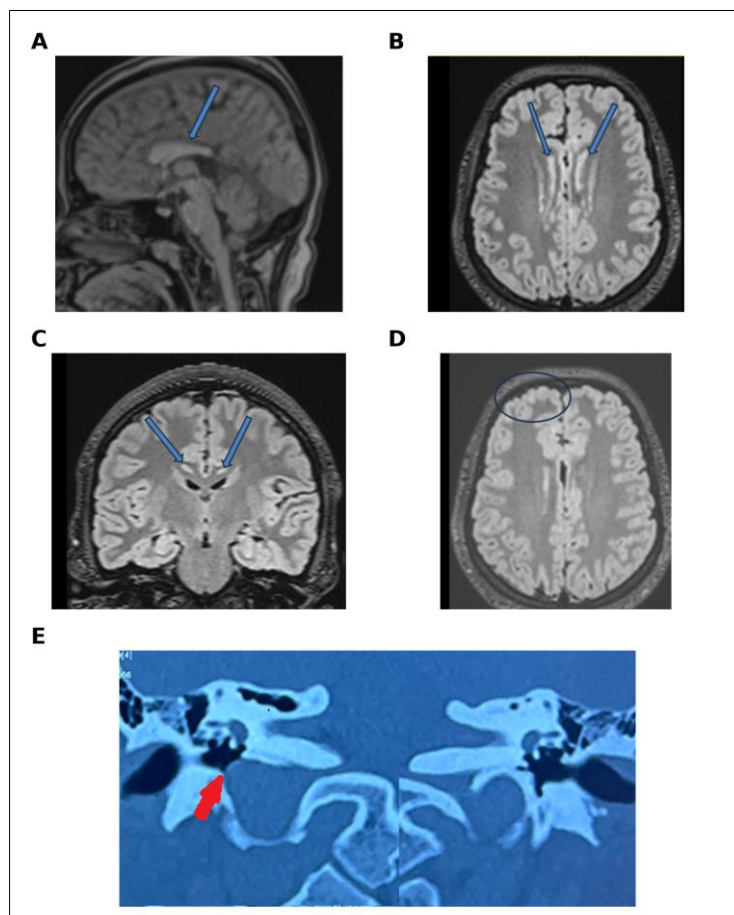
Brain MRI and temporal bone CT in Patient 1. A. Sagittal T1-weighted image showing partial agenesis of the corpus callosum. B. Axial 3D FLAIR image demonstrating bilateral symmetric pericallosal laminar gray matter heterotopia. C. Coronal 3D FLAIR image confirming bilateral pericallosal laminar heterotopia. D. Axial 3D FLAIR image showing bilateral parasagittal frontal polymicrogyria. E. Coronal temporal bone CT image showing a high-riding dehiscent jugular bulb with intratympanic protrusion, closely related to the round window region, which influenced side selection for cochlear implantation.
